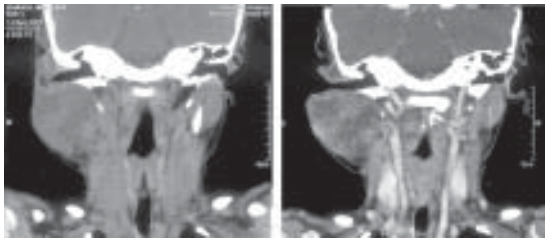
CT Scan showing the right sided parotid region swelling involving deep and superficial part size 6 x 5 cms with vascular enhancement post contrast confirming a haemangioma.
